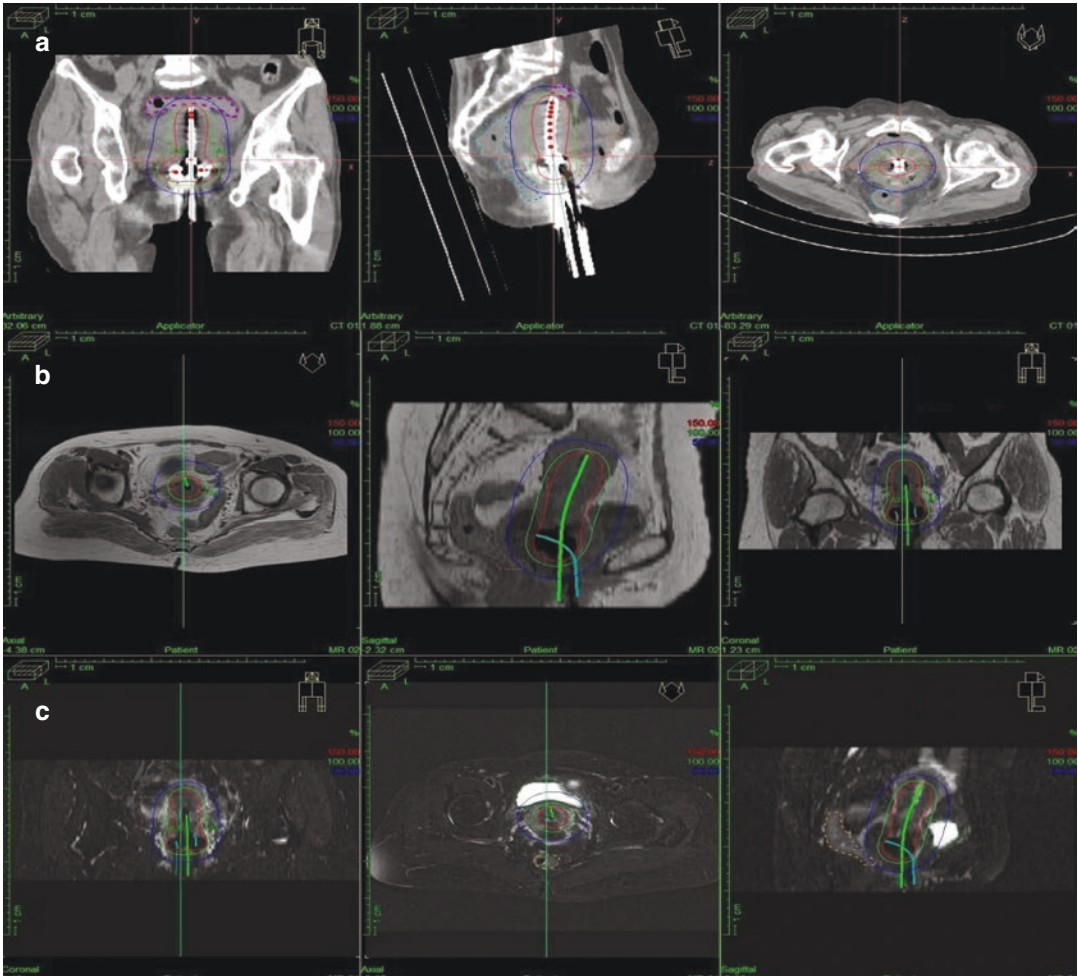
Catheter reconstruction in (a) CT image (b) T1 MRI image (c) T2 MRI image
